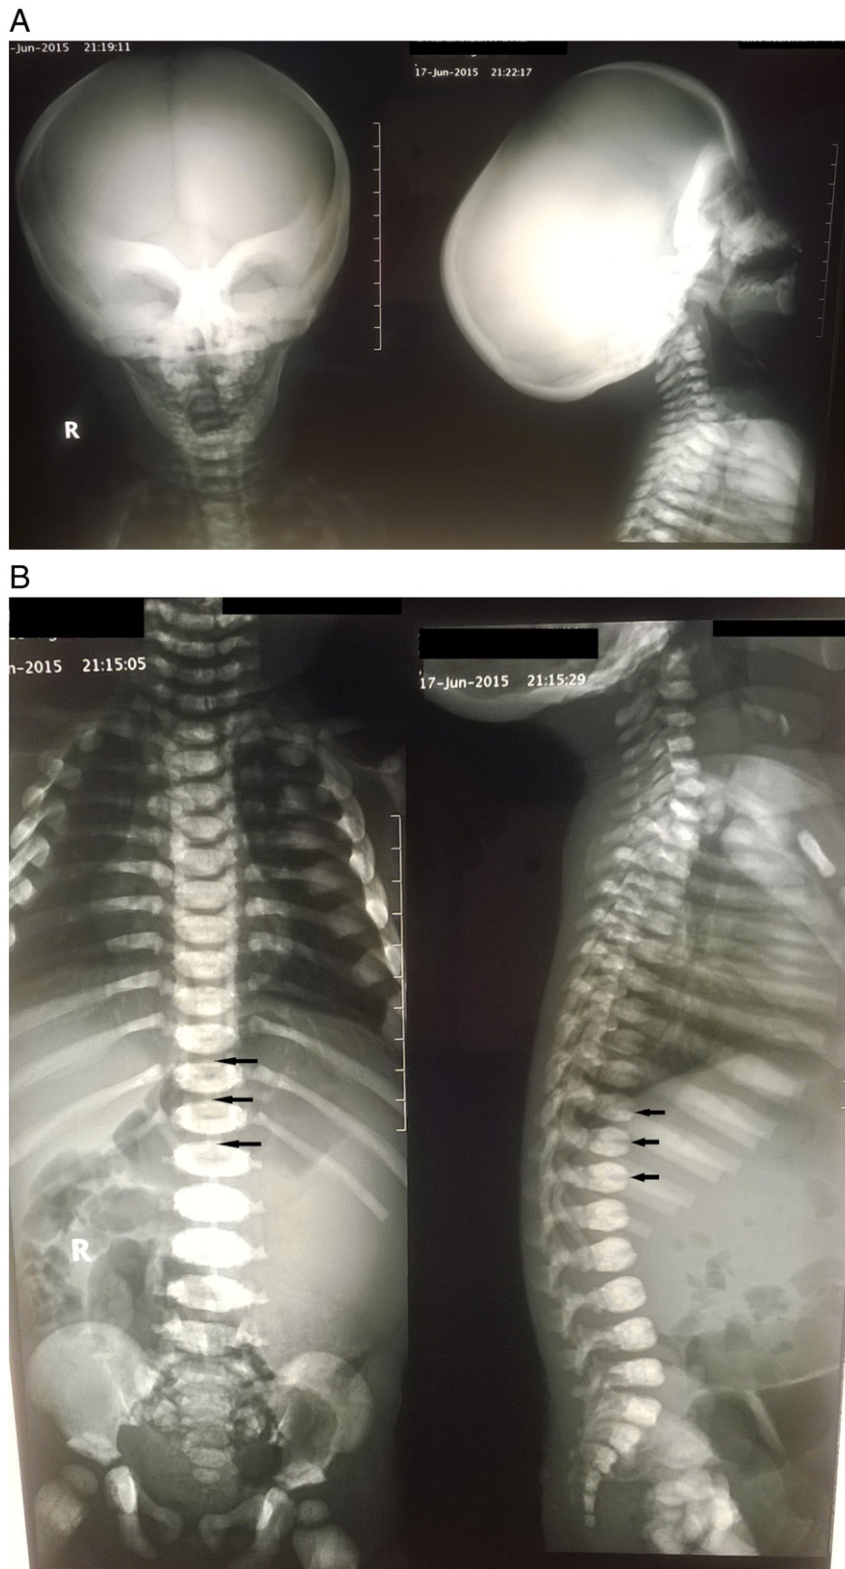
Anteroposterior and lateral radiographs of the skull (A) and the spine (B) demonstrating an overall increased density of the bones with fundamental involvement of the medullary portion. Note the classic endobone or “bone-within-bone” appearance in the spine, the “sandwich vertebra” appearance, characterized by dense endplate sclerosis with sharp margins (black arrows).
